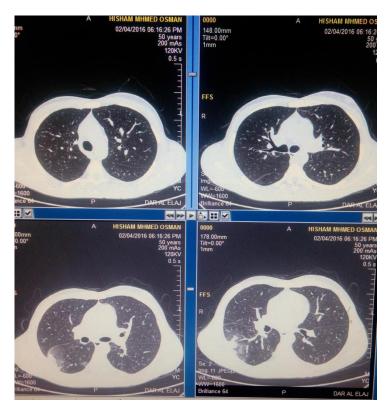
HRCT axial chest for male 50 years old show pneumonic consolidation.
